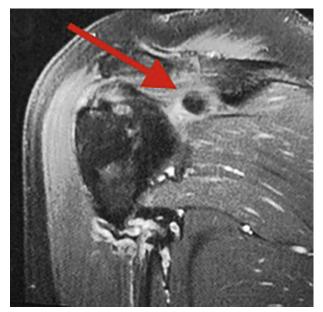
Magnetic resonance imaging (T2) right shoulder. Intramuscular calcification of the supraspinatus (arrow).
